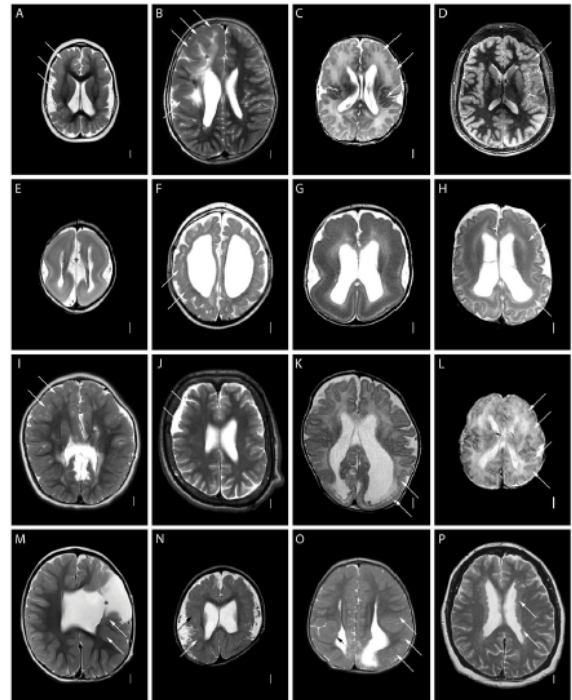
MRI of patients with different forms of MCD. Arrows highline the presence of malformation at level of the cortex. Figure adapted from [4].
